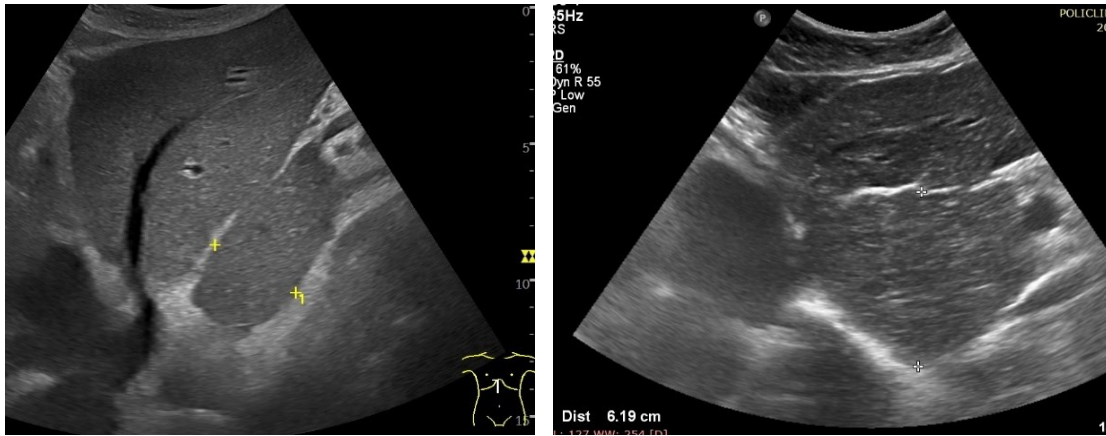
A-B. Ultrasound Findings of Normal (A) and Enlarged Caudate Lobe (61 mm) (B)
